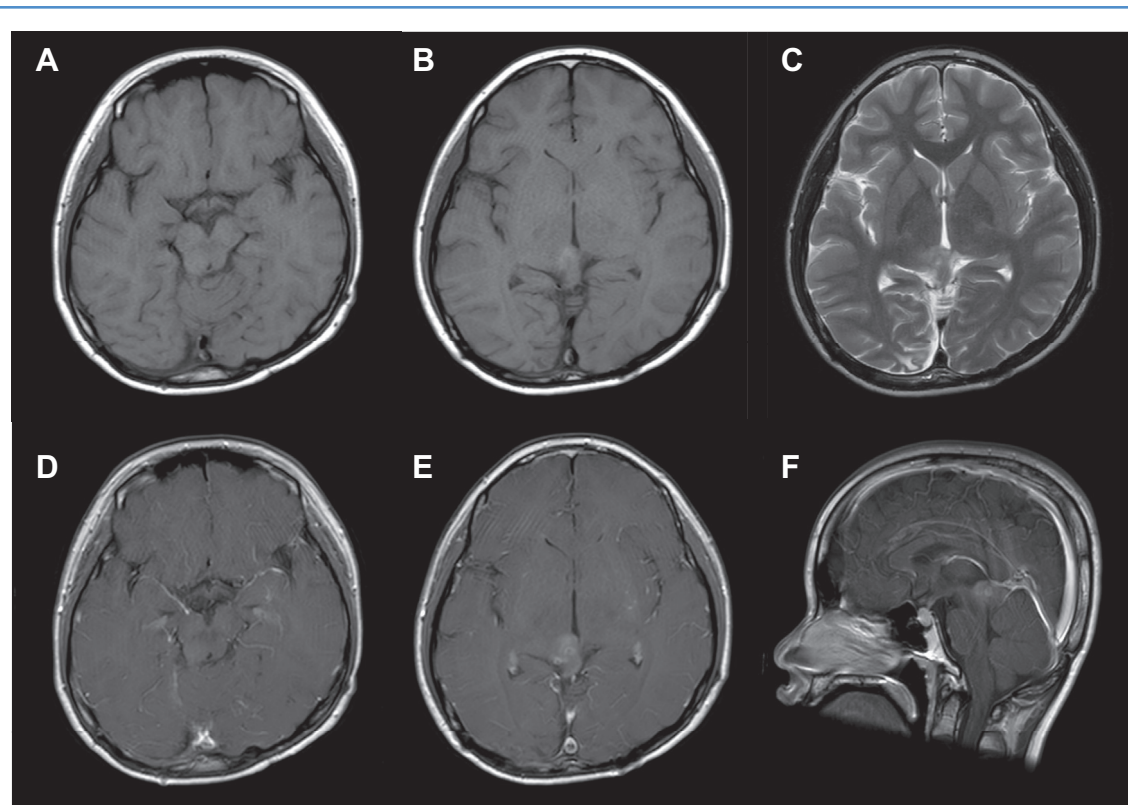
Postoperative magnetic resonance imaging (MRI). (A and B) Axial T1-weighted images; (C) axial T2 weighted image; (D and E) gadolinium-enhanced T1-weighted axial images; (F) gadolinium-enhanced T1-weighted sagittal image. The residual
